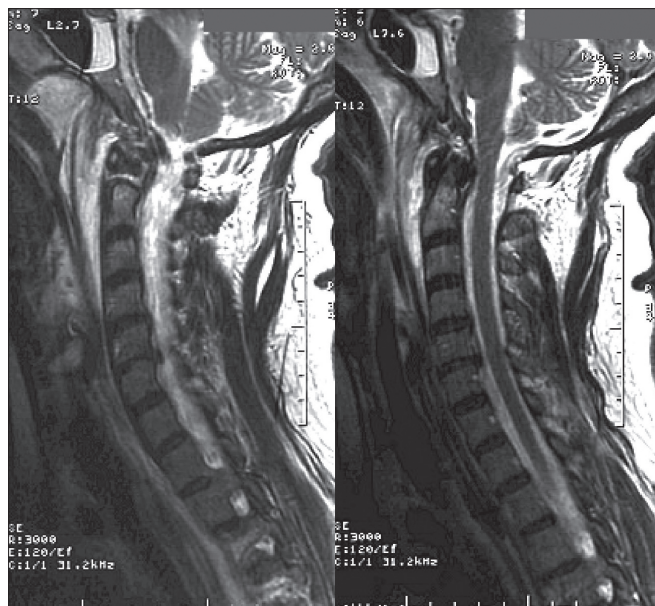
MRI of the spinal cord contusion and epidural hematoma are shown
